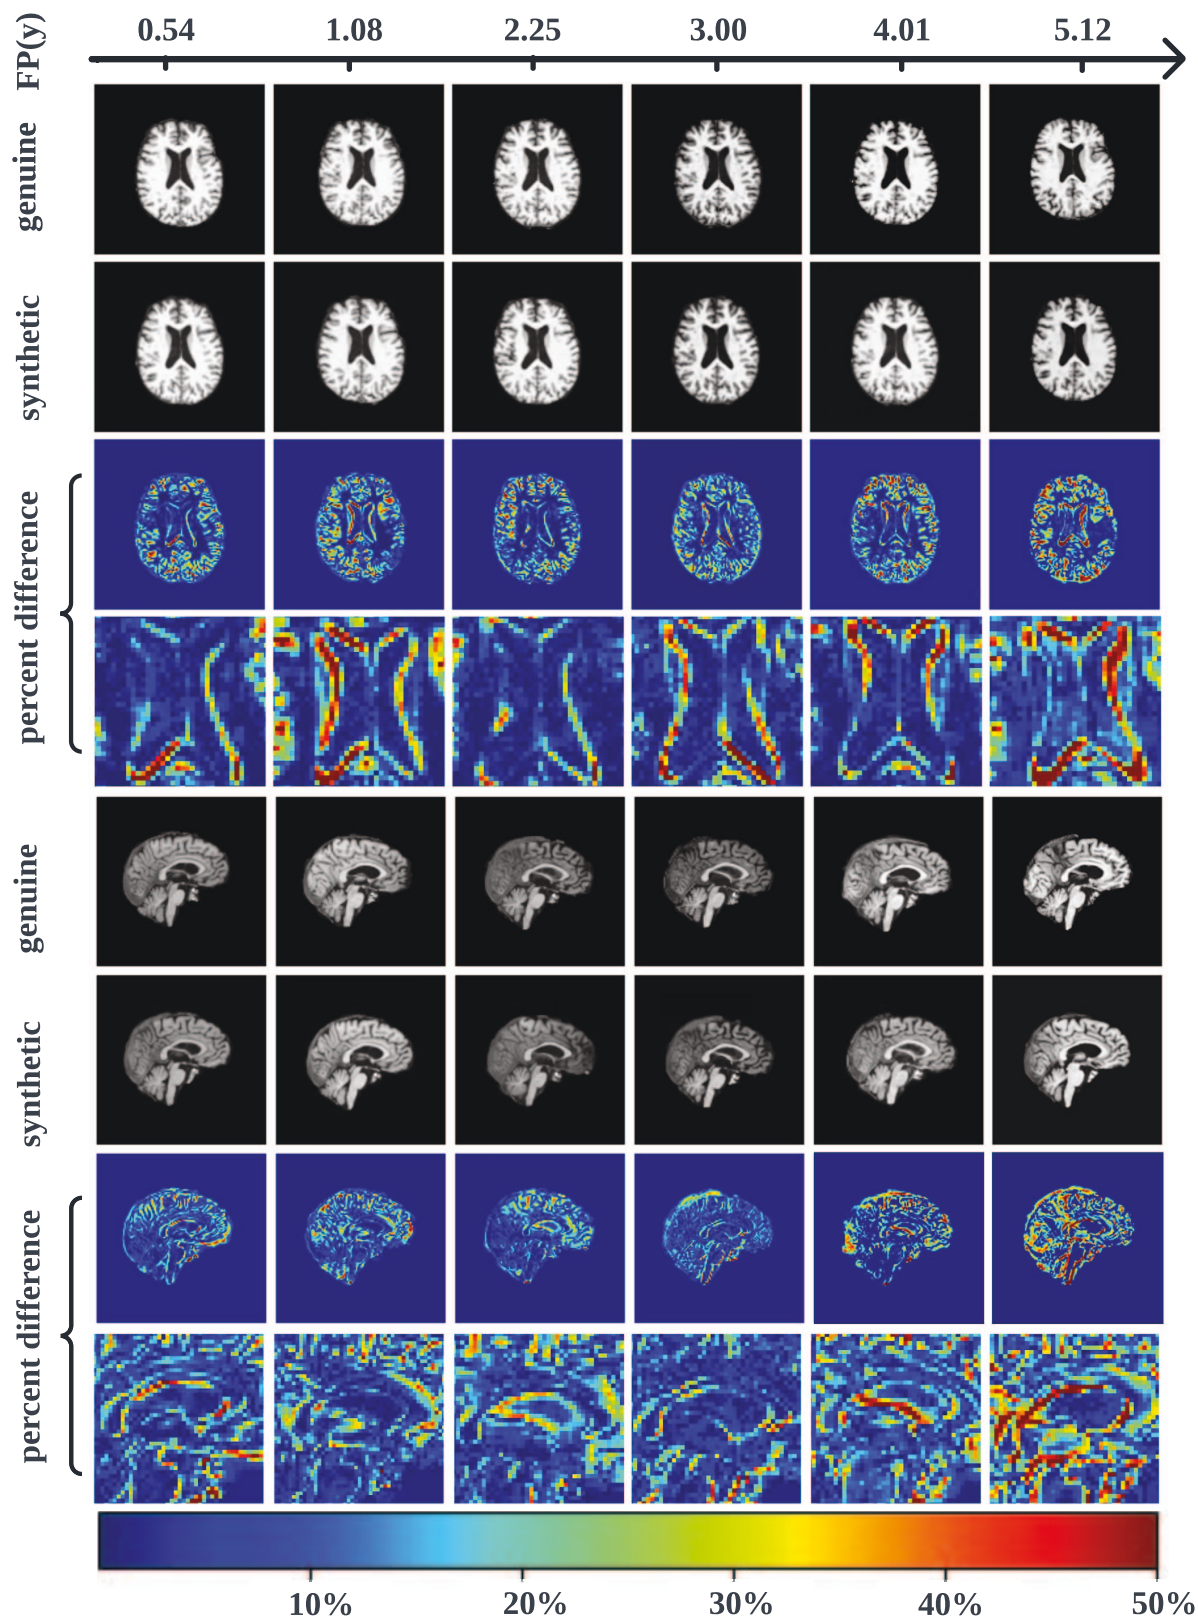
Brain evolution. Comparison of genuine (row 1, row 5) and synthetic (row 2, row 6) for both axial and sagittal MRI slices for a participant aged 76.3 years at baseline. Future brain scans are predicted for six follow-up periods (*FP*) post-baseline (columns 1 through 6). Percentage differences between synthetic and genuine MRIs are displayed in row 3, 4, 7 and 8 with detailed views of the ventricles in rows 4 and 8.
